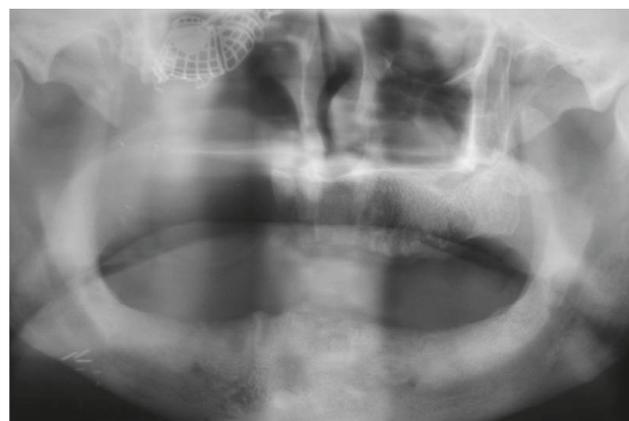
Panoramic radiograph showing the maxillary defect. A titanium mesh was placed at the inferior border of the right orbit to support the orbital content. No signs of bony reconstruction were noted on the right maxillary defect.
